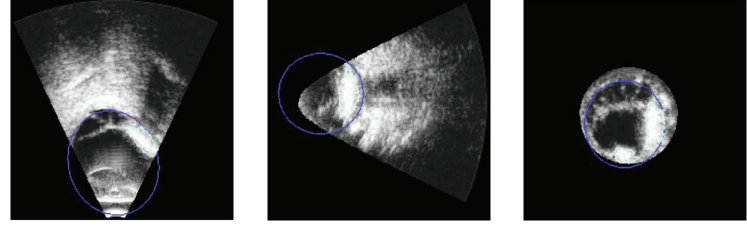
3D US image with the superposed eye ball contours from the CT image, after applying the object-based transformation
